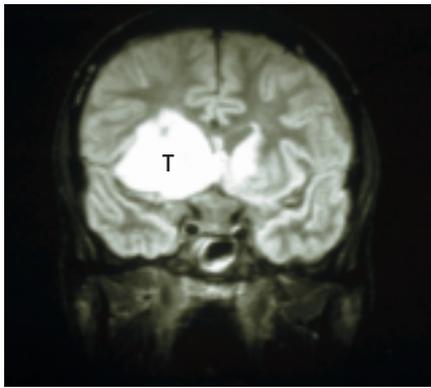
Nuclear magnetic resonance imaging scan of the brain of an HIV-infected patient showing a large lymphoma (T) in the basal ganglia.
